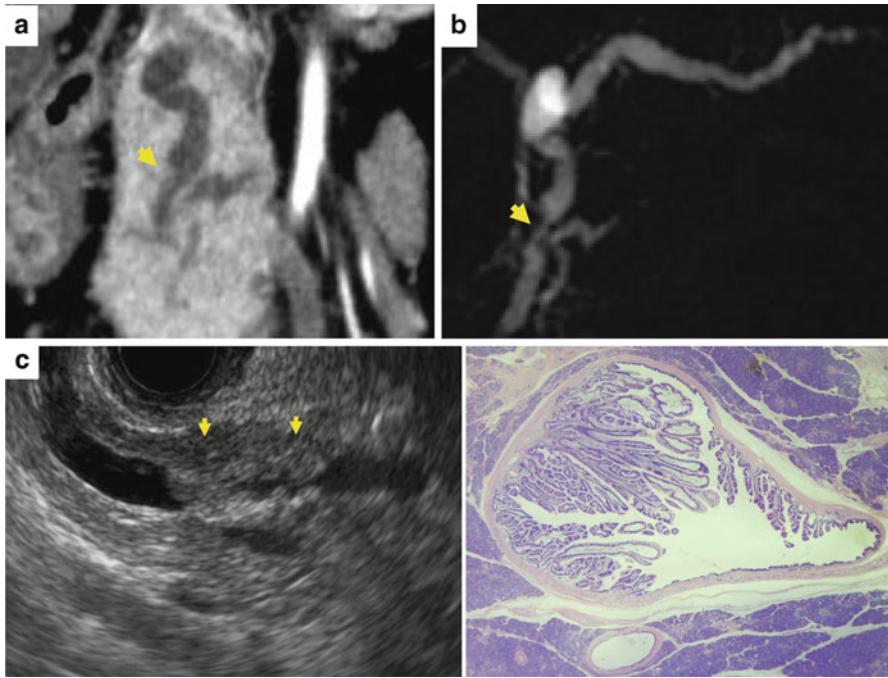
MD-IPMN CT and MRCP found dilatation of MPD and stenosis in pancreatic head but could not detect the mural nodule. EUS could detect the MN in MPD
